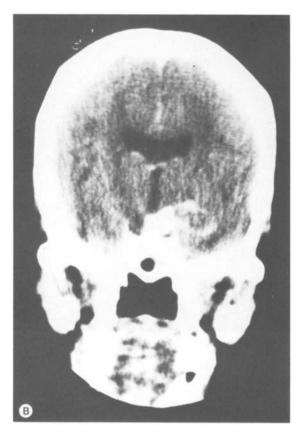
A: axial and B: coronal enhanced CT scans after the eighth course of chemotherapy. Notice the significant decrease in the product of the two largest diameters of the cystic portion when compared with that of the pretreatment CT scan (Fig. 2).
